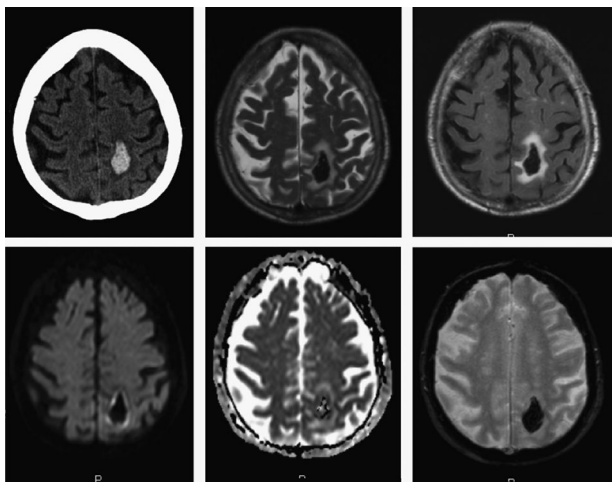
CT and MRI images of an acute left parietal acute intracerebral haemorrhage. The top left hand image is CT. The remaining images are all MRI sequences and are from left to right. Top row: T2-weighted, FLAIR; bottom row: DWI, ADC map, gradient echo. © Anthony Pereira.
